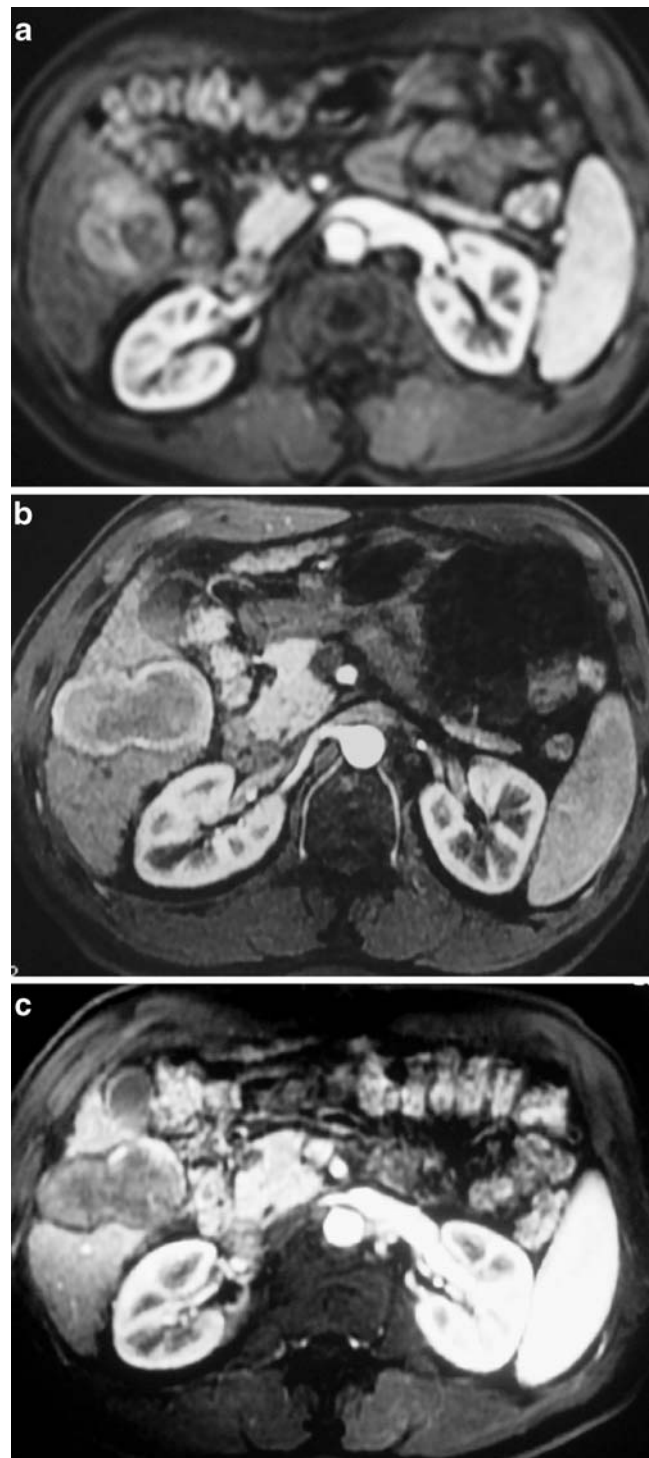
Microwave ablation under the temperature monitoring assisted with ethanol injection for a 58 mm HCC mass close to the bowel loop. a MRI showed a protruding hypervascular mass in segment 8 abutting the bowel loop. b One month after two sessions of microwave ablation under the temperature monitoring and adjuvant 9-ml ethanol injection, the nodule was completely ablated and showed on contrast-enhanced MRI. The patient suffered no complications. c Twelve months after microwave ablation, the nodule had no local tumor progression on contrast-enhanced MRI.
